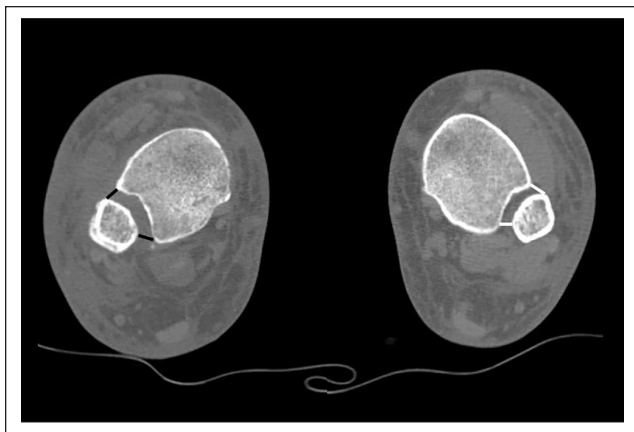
Anteroposterior difference was calculated as the distance between the anterior and posterior facets of the tibial incisura and the fibula. This patient (from Figure 1) underwent the anatomic repair technique (ART). The operative side (black) is compared to the uninjured side (white) on computed tomography (CT) at 3 months postoperatively.
